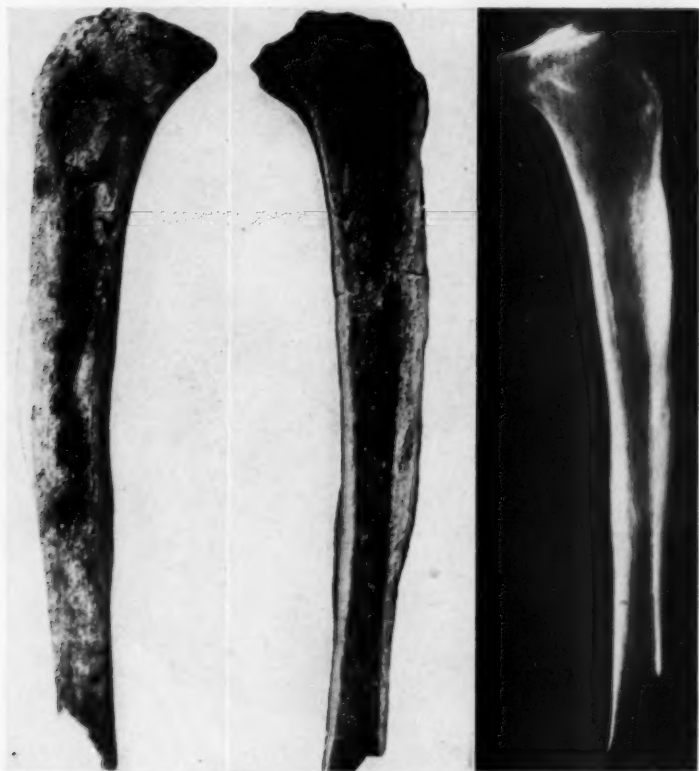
Long bone of a prehistoric Mound Builder, Ohio, Fort Ancient Culture. The right tibia (anterior surface), the vertical section and the roentgenogram are shown. The left tibia in the same case is shown in figure 40. This is case 2 from Ohio, this article. (Original photographs.)
